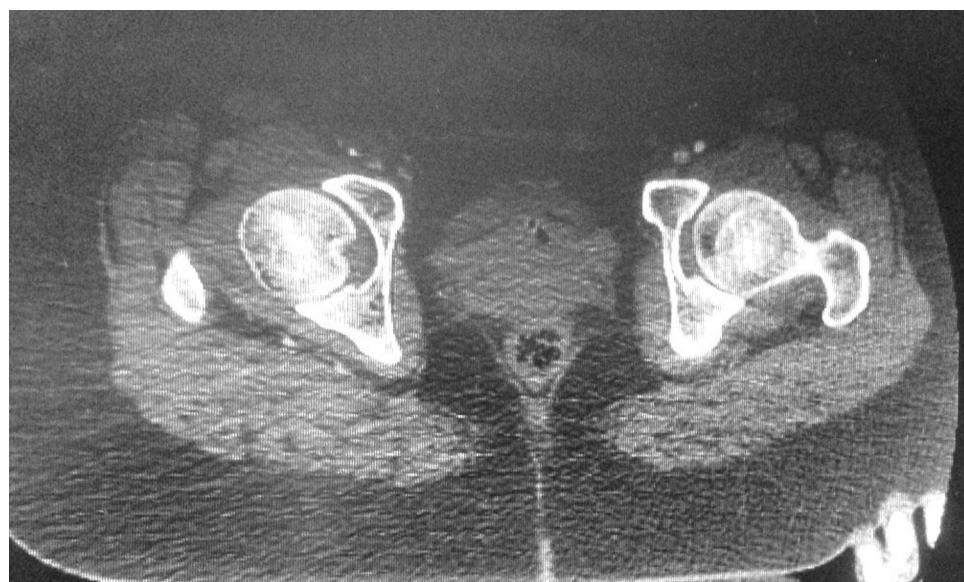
Axial CT image of the left hip after reduction.
